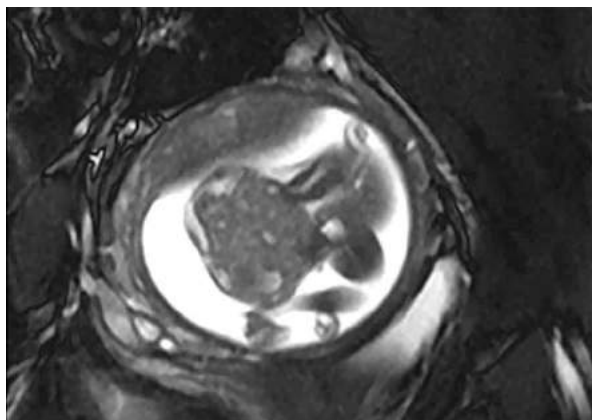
MR image T2-weighted trufi HQ (TR 214.1ms, TE 1.76ms) in the axial plane shows a mainly solid tumor tissue with small areas of microcystic content
